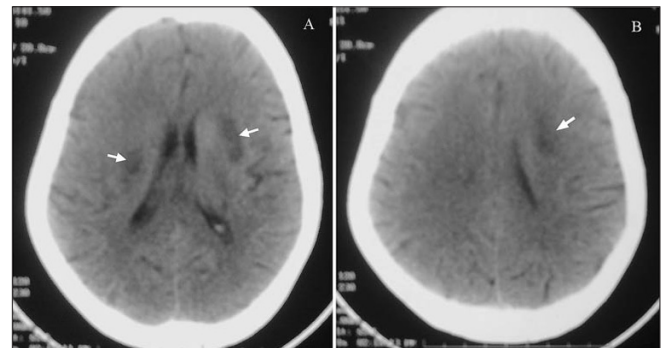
Noncontrast computed tomography scan of the brain. Arrowheads show bilateral basal ganglia infarcts
